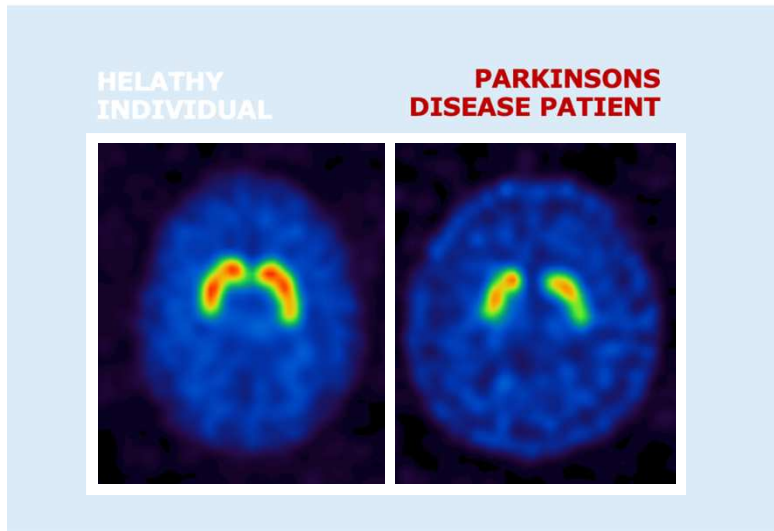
Dopamine Transporter Scan Using Single-Photon Emission CT.
